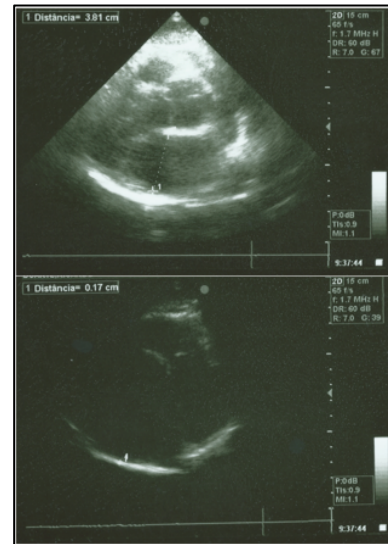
shows echocardiograms of Mr. R [13-15]. *Top image:* Gain set at 67. *Bottom image:* Gain set at 39.
